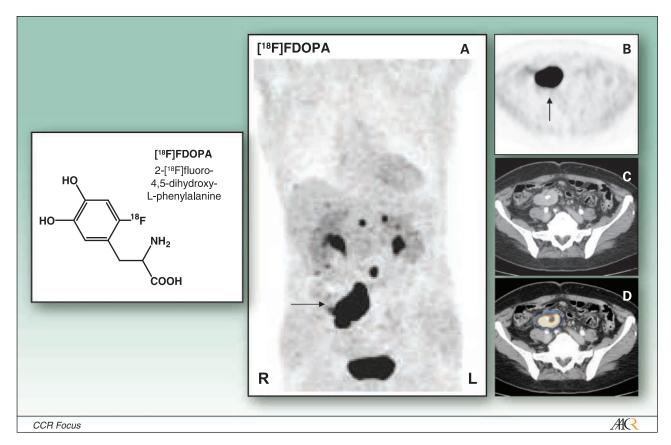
[18F]FDOPA. [18F]FDOPA-PET/CT of a patient with neuroendocrine carcinoma. Intense focal tracer uptake in the primary tumor (*arrow*) and multiple lymph node and liver metastases are seen. *A*, maximum intensity projection of [18F]FDOPA-PET. *B*, transaxial section of [18F]FDOPA-PET. *C*, corresponding transaxial section of CT. *D*, fused image ([18F]FDOPA-PET/CT). Transaxial sections indicate the primary tumor (PET images kindly provided by Dr. S. Reske).
